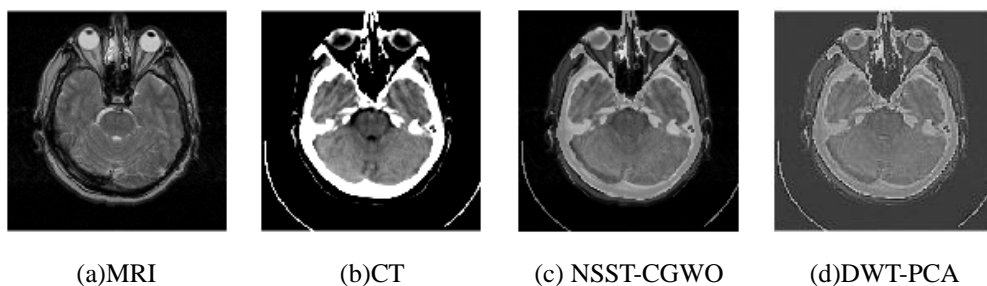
Qualitative outcomes of sarcoma (CT-MRI-T1)
